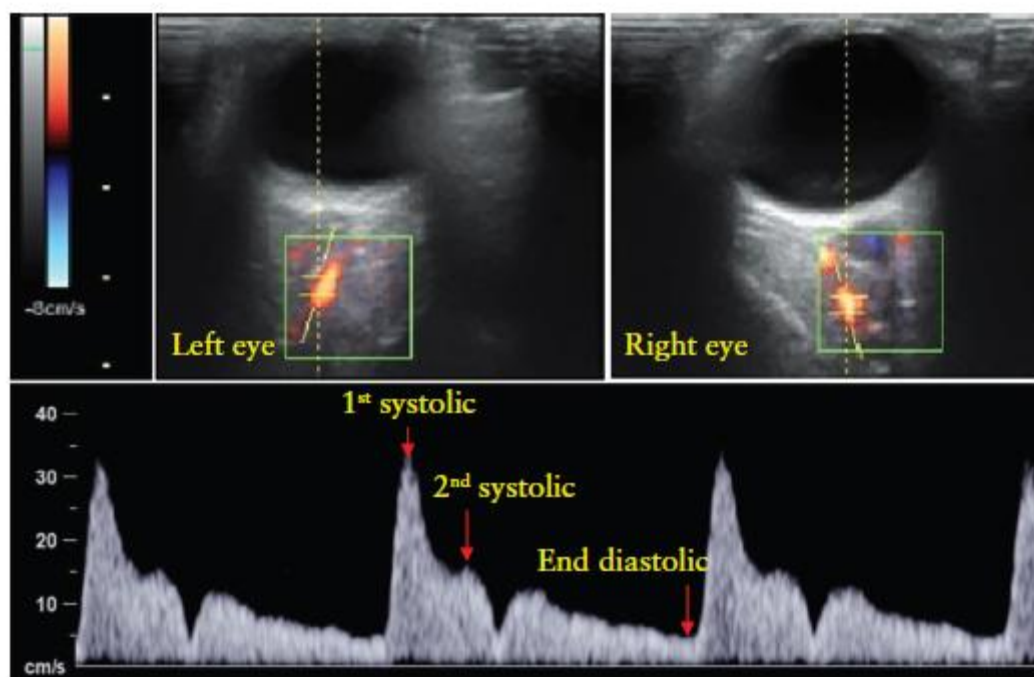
OAD - Left and Right Pulsed-wave Doppler flow velocity waveform from the ophthalmic artery, which displays the first and second peaks of the systolic and end-diastolic velocities, is shown at the bottom
